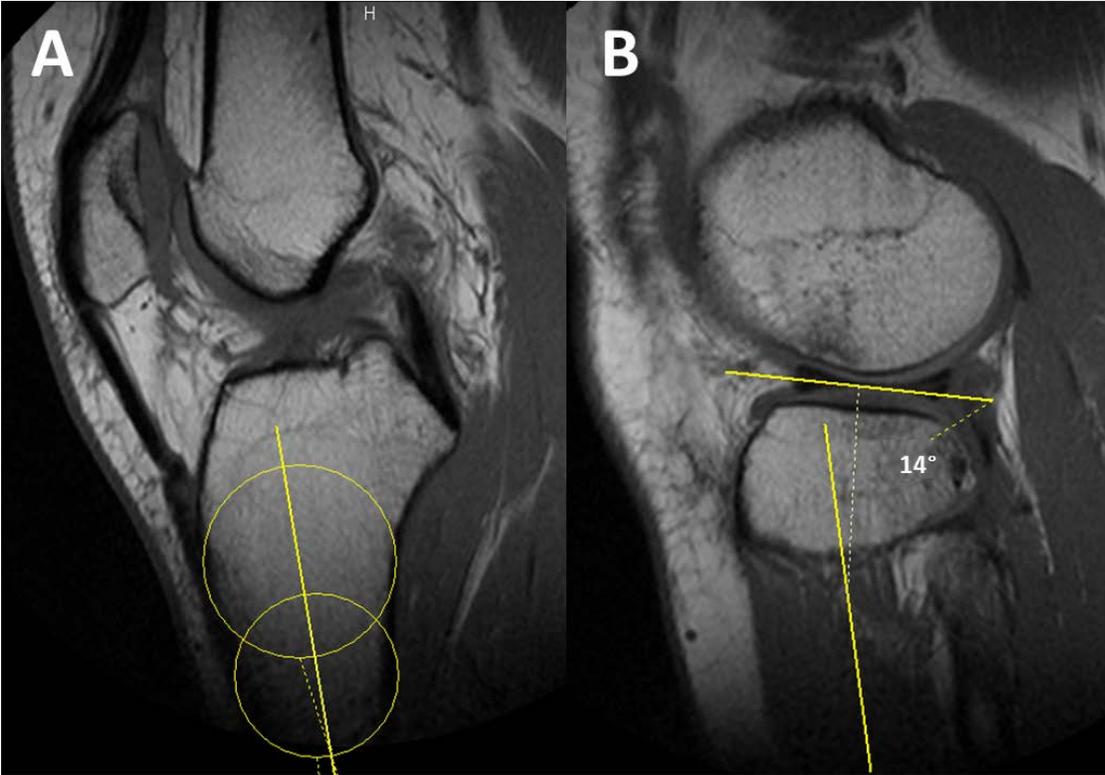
Measurement technique for determining lateral posterior tibial slope on magnetic resonance imaging. A) Midsagittal plane identifying the center of the tibial axis. B) Determination of lateral posterior tibial slope angle (degrees), measuring 14 degrees in a patient with a noncontact ACL tear.
